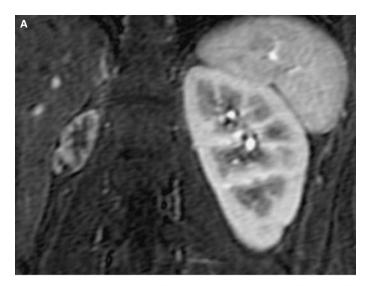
Contrast-enhanced CT in a patient with acute pyelonephritis showing the characteristic wedge-shaped defects in the right kidney. In addition, subtle defects are present in the left kidney.
